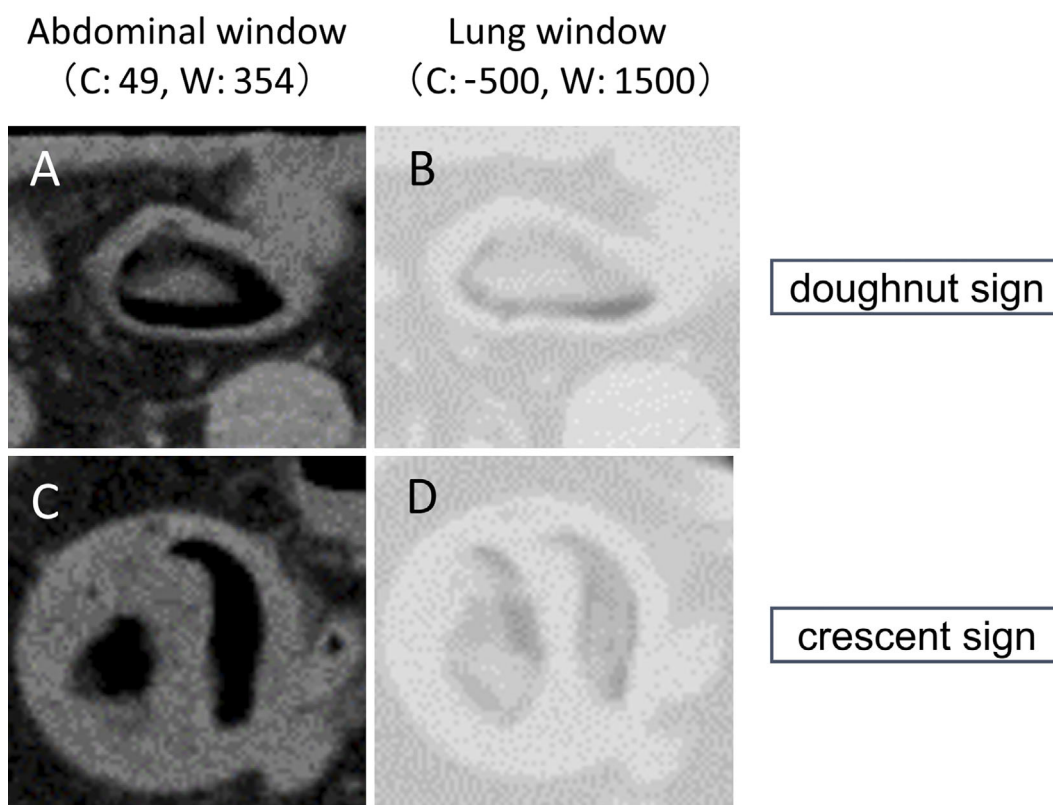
“Doughnut sign” (A, B) and “crescent sign” (C, D) on computed tomography. Each sign is depicted on both the abdominal window setting (A, C) and lung window setting (B, D).
